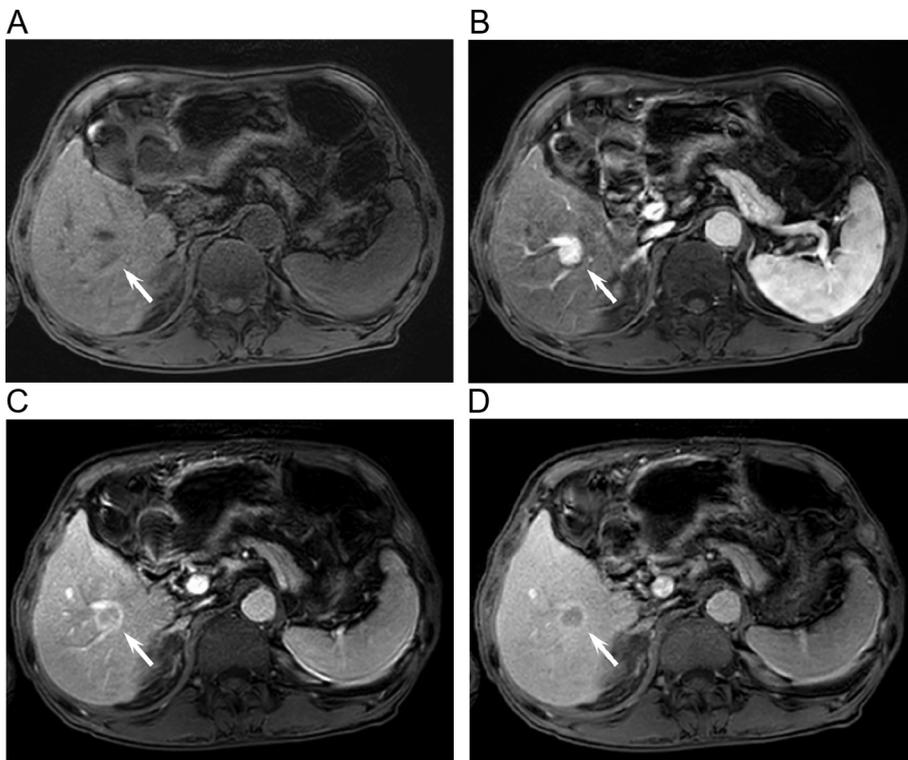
A 66-year-old male with chronic hepatitis B. Gadoteric acid-enhanced dynamic MR imaging with eTHRIVE (A, pre-contrast; B, hepatic arterial phase; C, portal venous phase; D, transitional phase) demonstrated acceptable image quality with moderate motion artifacts (overall image quality scores of 3 for A and B, and 4 for C and D).
